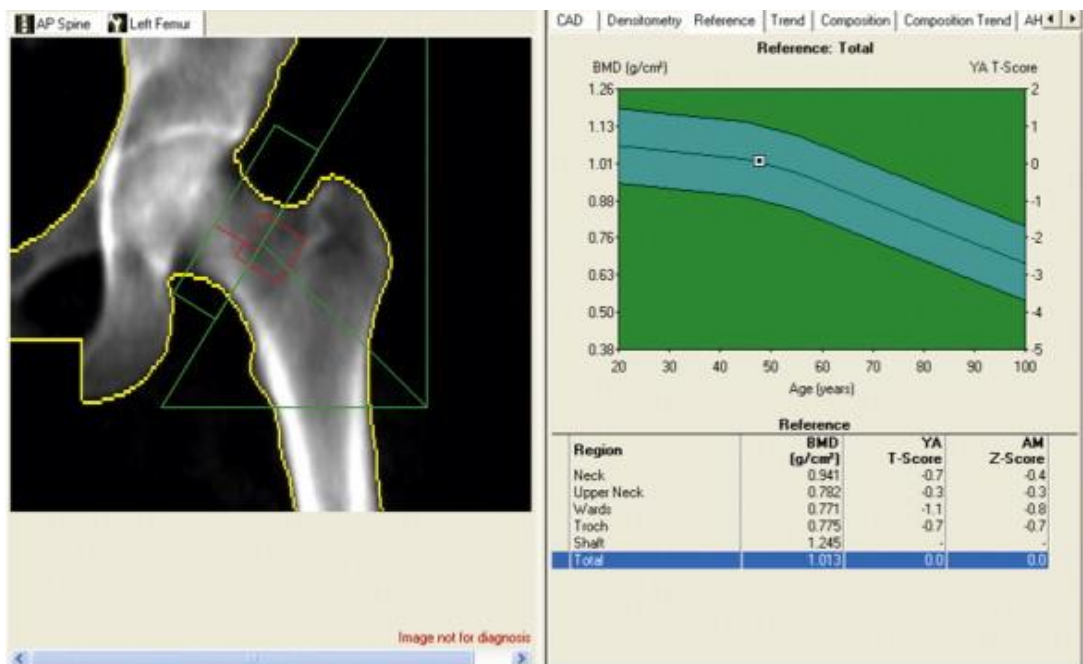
Dual-energy X-ray Absorptiometry-based assessment of the femoral neck, with both T and Z score references values. Adapted from Burr & Allen (2013).
